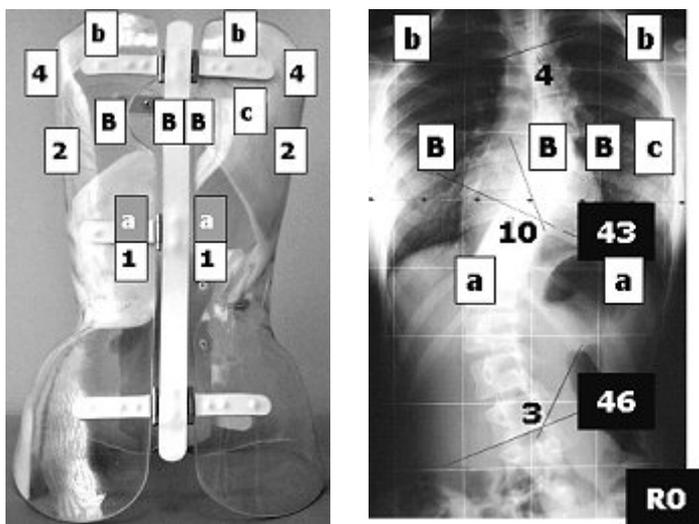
Action of kyphotisation according to SPoRT concept for thoracic scoliosis in the posterior-anterior and radiographic views.
